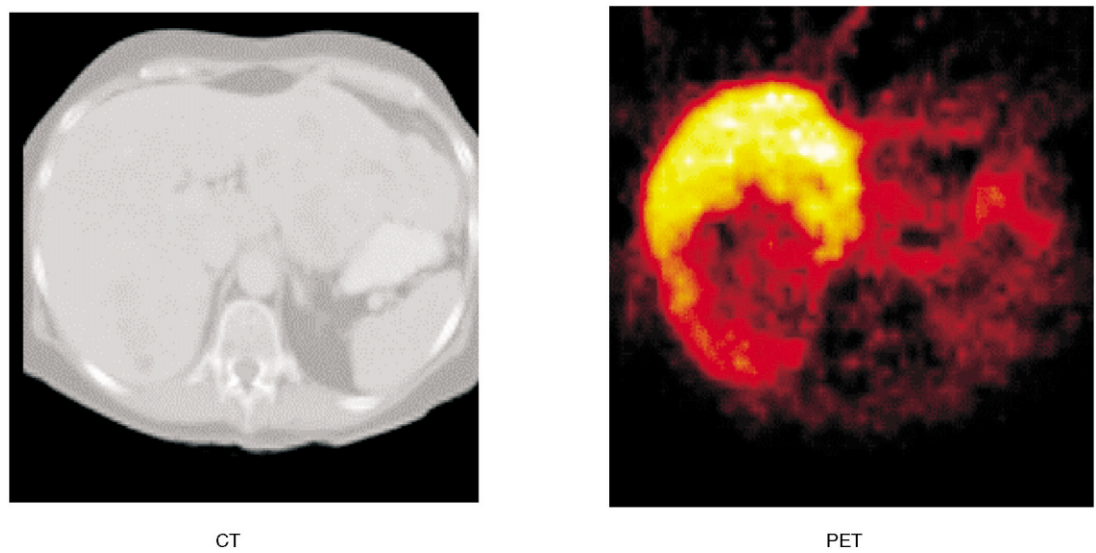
Transaxial Computed Tomography (CT) (Left) and PET image after injection of 5-[<sup>18</sup>F]FU (right) of the abdomen of a patient with meta-static colorectal carcinoma. Images show liver with metastasis in left lobe, with corresponding large photopenic area seen on PET scan.
